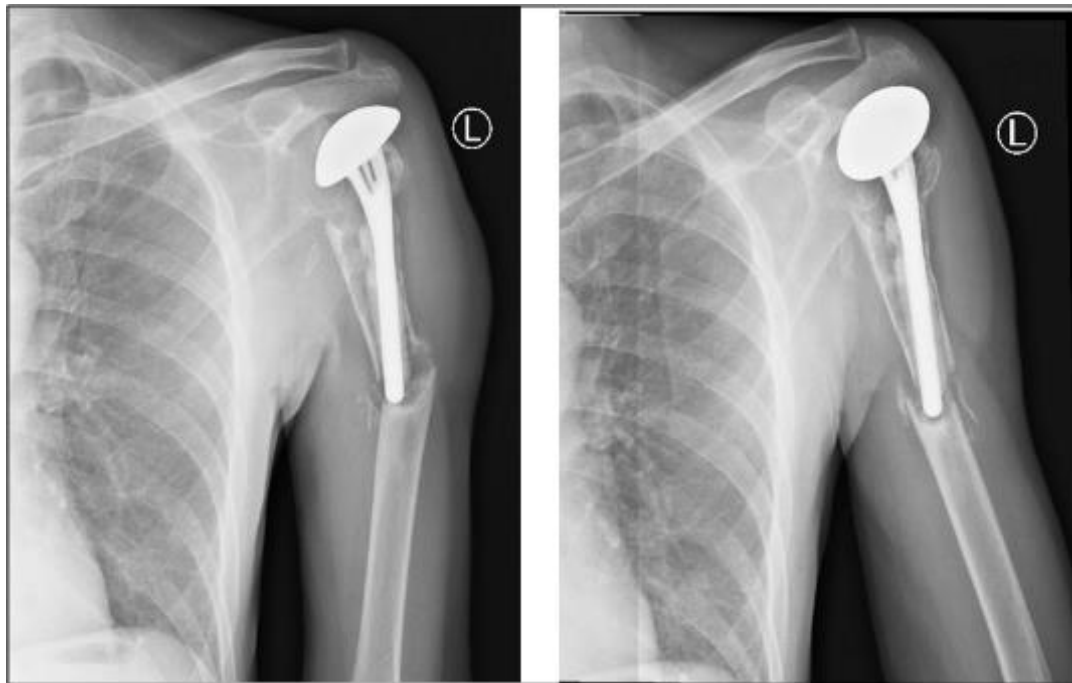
Left humerus X-ray taken upon admission to the emergency department
